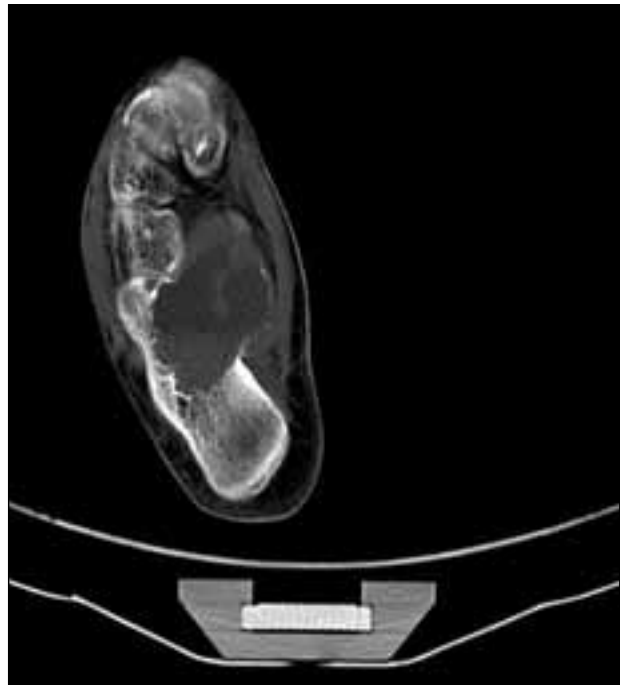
Axial CT image demonstrating aneurysmal bone cyst with blood fluid level
